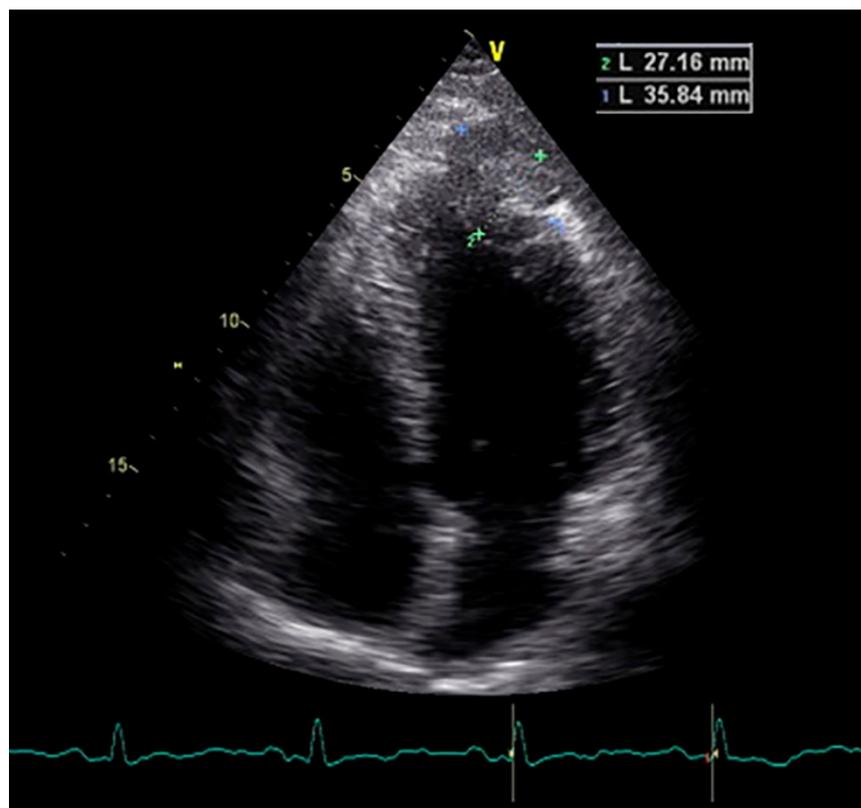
Echocardiogram revealed an echogenic mass of irregular appearance in the left ventricular apex
